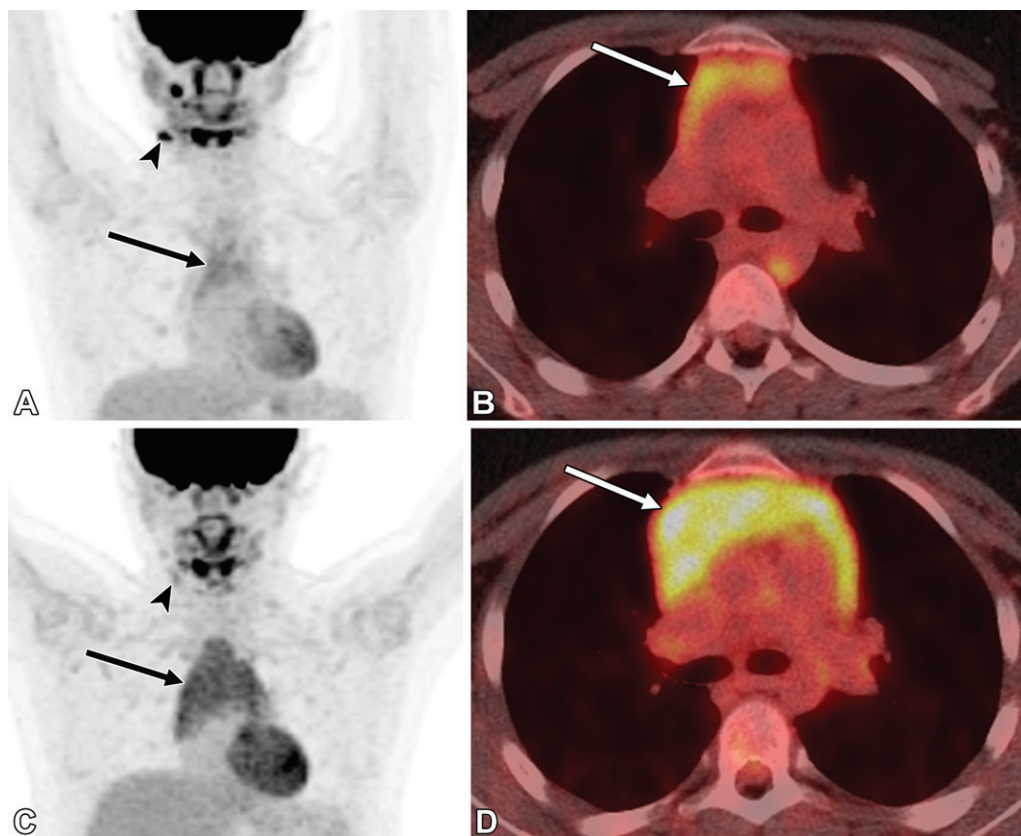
Rebound thymic hyperplasia in a 13-year-old boy with Hodgkin lymphoma following completion of chemotherapy. (A, B) Initial staging maximum intensity projection FDG PET (A) and transaxial fused FDG PET/CT (B) images show hypermetabolic right cervical lymphadenopathy consistent with biopsy-proven lymphoma (arrowhead in A), with physiologic thymic uptake seen in the anterior mediastinum (arrow). (C, D) Restaging maximum intensity projection PET (C) and transaxial fused FDG PET/CT (D) images 6 months after completion of chemotherapy show decreased avidity of the right cervical lymphadenopathy, consistent with treatment response (arrowhead in C). There is also interval diffusely increased size and activity of the thymus with maintained normal thymic morphology (arrow), most consistent with rebound thymic hyperplasia, which resolved at follow-up imaging without further treatment (not shown).
